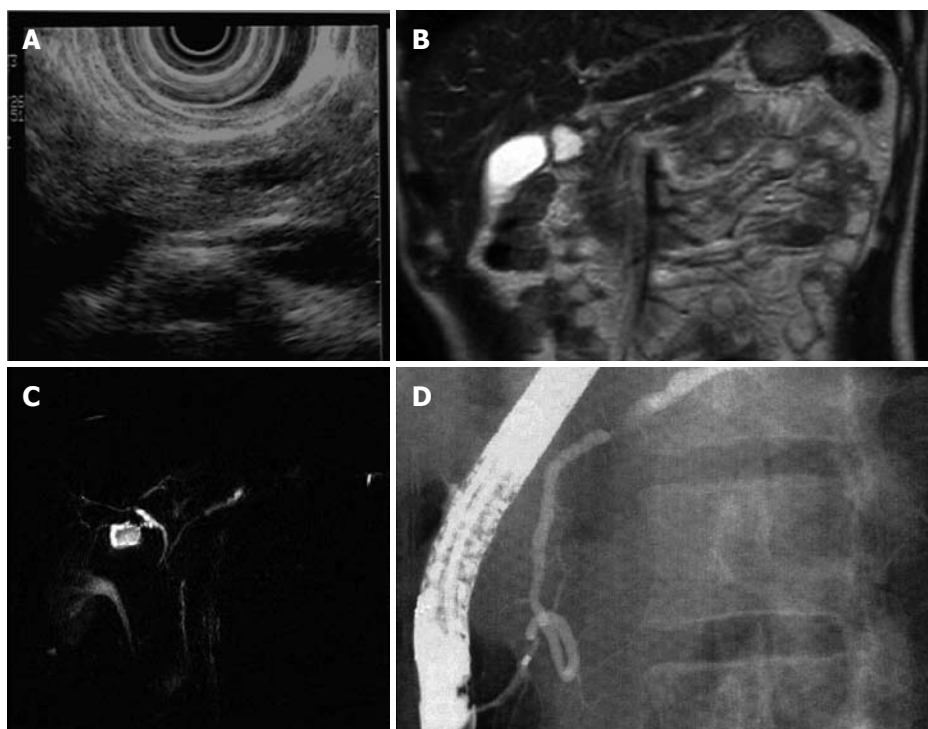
Dilation of the main pancreatic duct. Endoscopic ultrasonography was demonstrated presence of a small pancreatic tumor. A: Ultrasonography; B: Magnetic resonance imaging; C: Magnetic resonance cholangiopancreatography; D: Endoscopic retrograde pancreatography.
